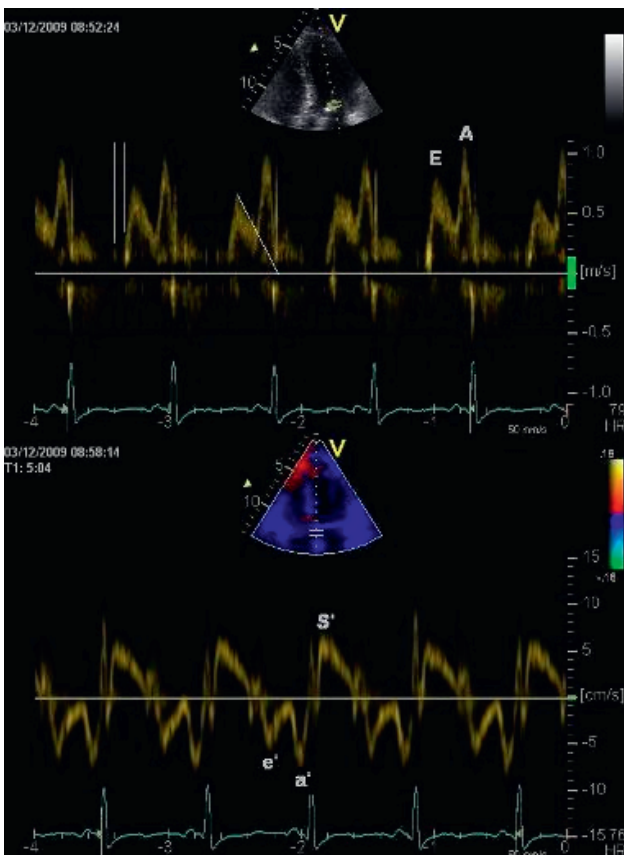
Patient with hypertension and diastolic dysfunction. The image at top shows reduced E/A ratio, prolonged IVRT and prolonged deceleration time. The image below shows reduced tissue Doppler velocity, e' (85).
